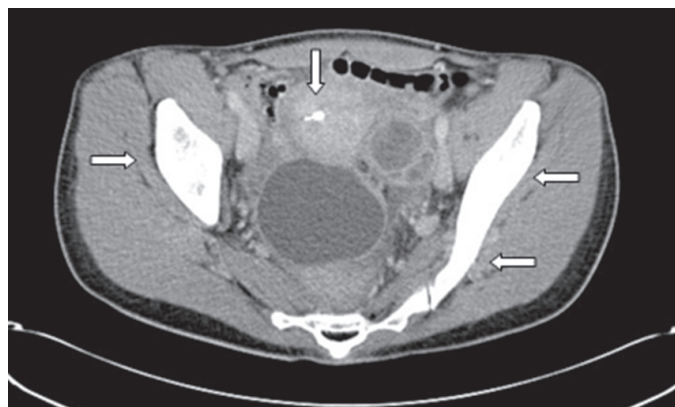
Axial computed tomography imaging of patient, upon admission to hospital. The bilateral cystic ovarian masses are visualized and the IUCD can be seen in the endometrial cavity.
